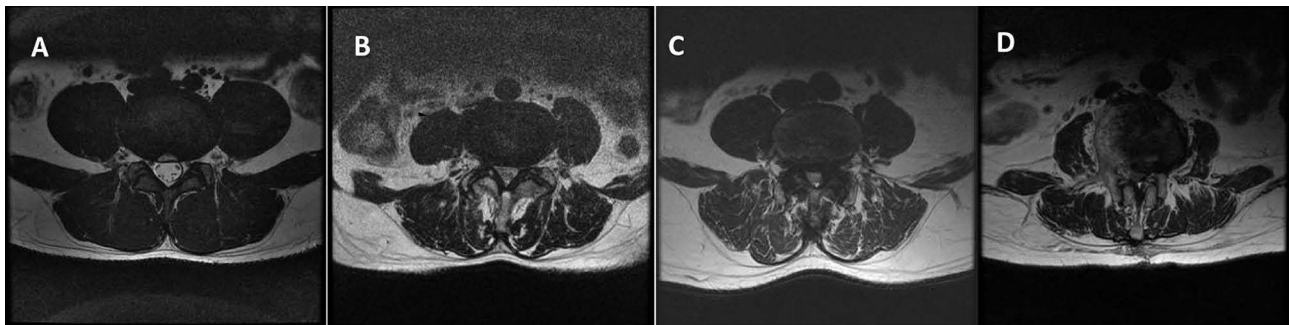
Severity classification of LSS on MRI ((A), cerebrospinal fluid is clearly visible in the dural sac; (B), the nerve root occupies the whole dural sac, but the shape of the nerve root can still be seen; (C), unclear nerve roots due to posterior epidural fat and invisible cerebrospinal fluid; (D), no posterior epidural fat and unclear nerve root).
